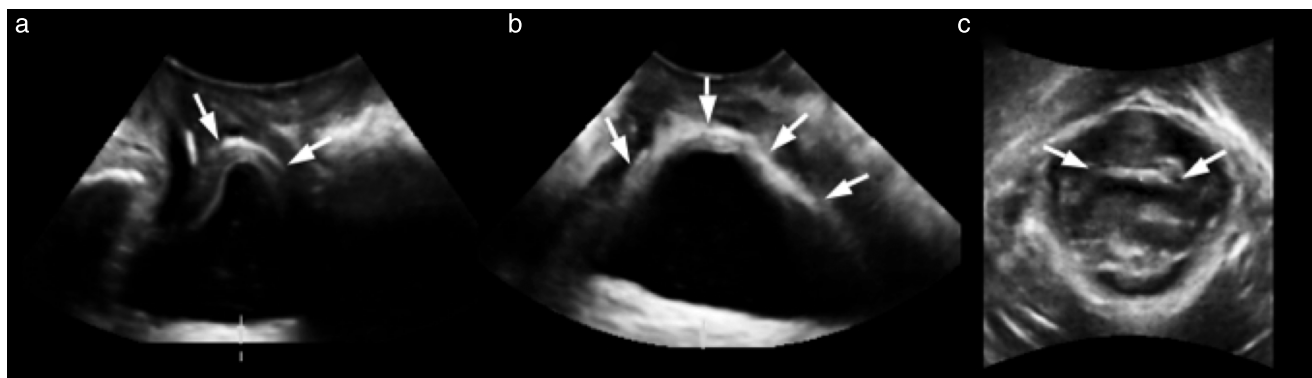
Mesh location (arrows) on four-dimensional transperineal ultrasound in mid-sagittal (a), coronal (b) and axial (c) planes on maximum Valsalva.
